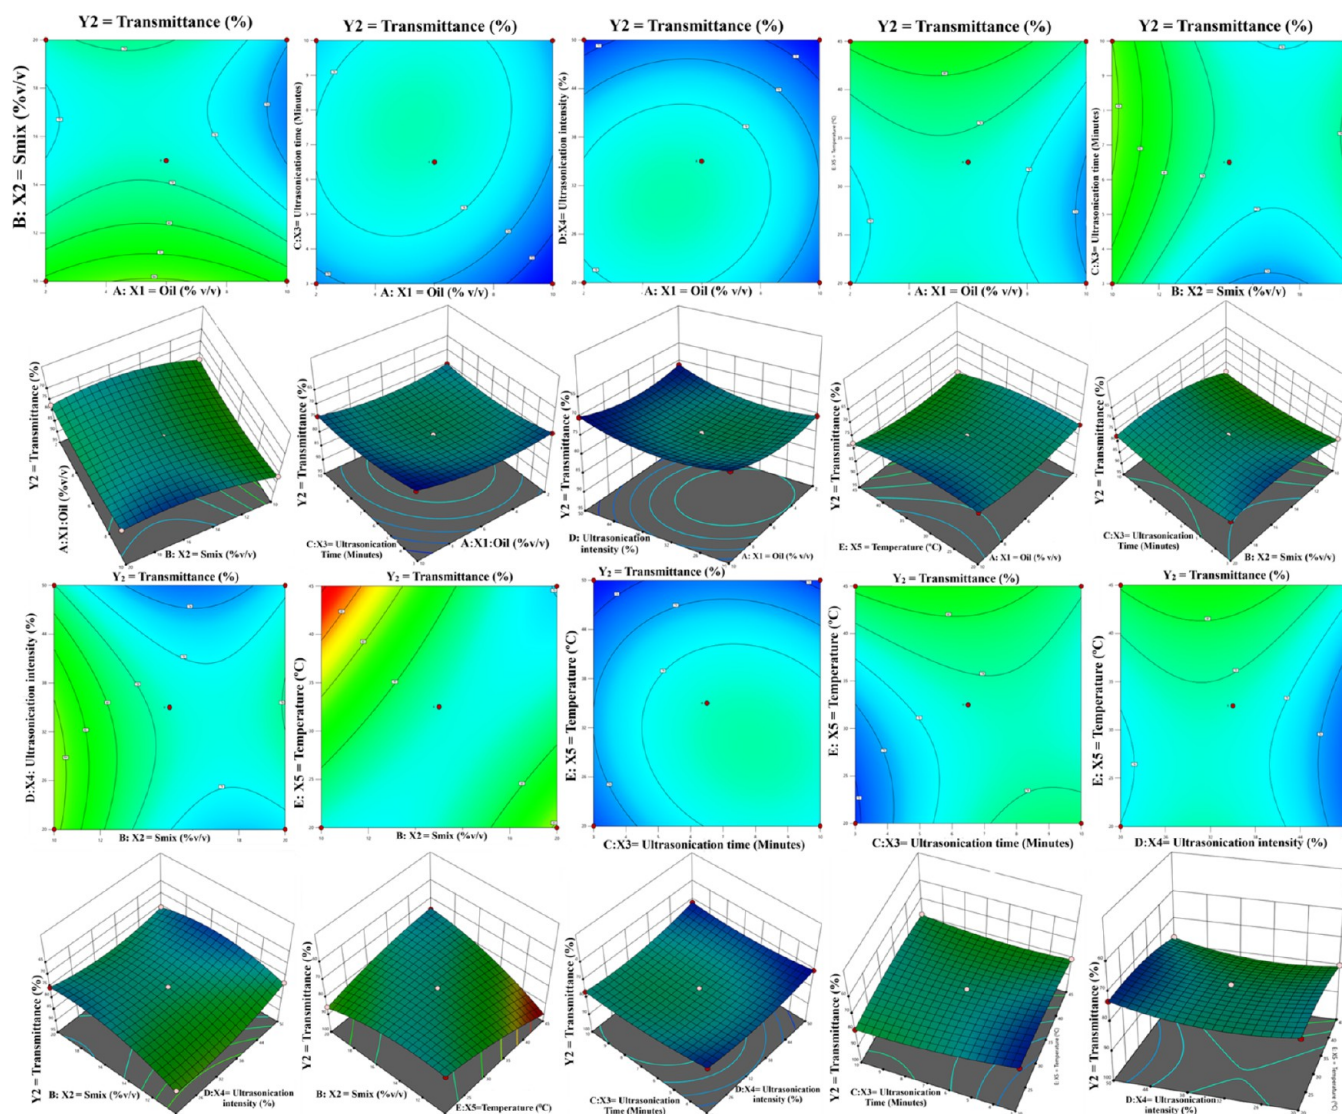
Effect of Capryol 90: oil phase (A), Smix (B) [Tween 80: surfactant, PEG 400: cosurfactant], and ultrasonication speed (C) on percentage transmittance (Y_2).
